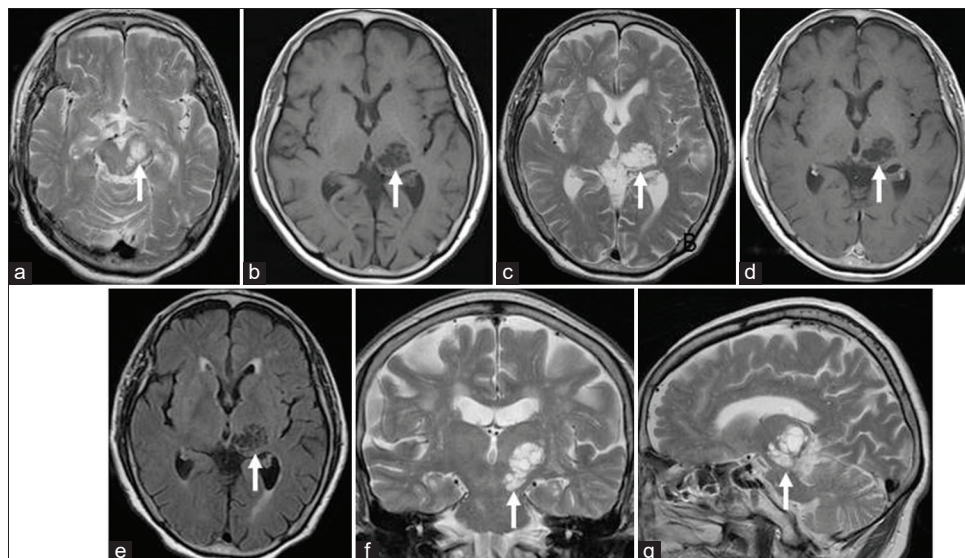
Magnetic resonance image (MRI) of giant perivascular spaces (PVSs) (arrows). (a) Axial T2-weighted image (T2WI) at the level of midbrain. (b-e) Axial images at the level of thalamus. (b) T1WI, (c) T2WI, (d) postgadolinium T1WI, (e) fluid-attenuated inversion recovery image. (f) Coronal T2WI. (g) Sagittal T2WI.
